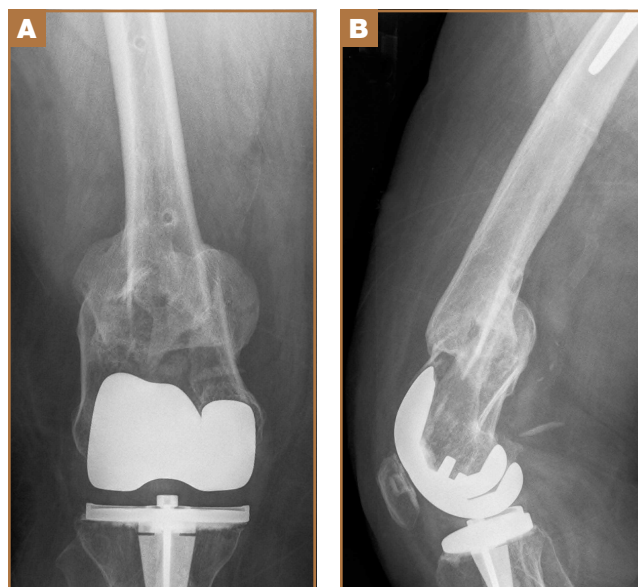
(A) Anteroposterior and (B) lateral radiographs of knee at 2-year follow-up, after spanning external fixation of knee.
